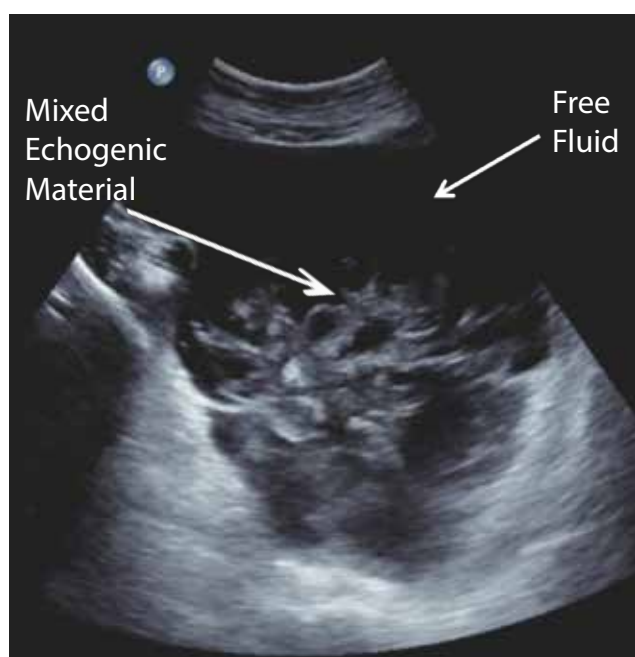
Sonographic image of the right iliac fossa demonstrating intra-abdominal free fluid and mixed echogenic material.
